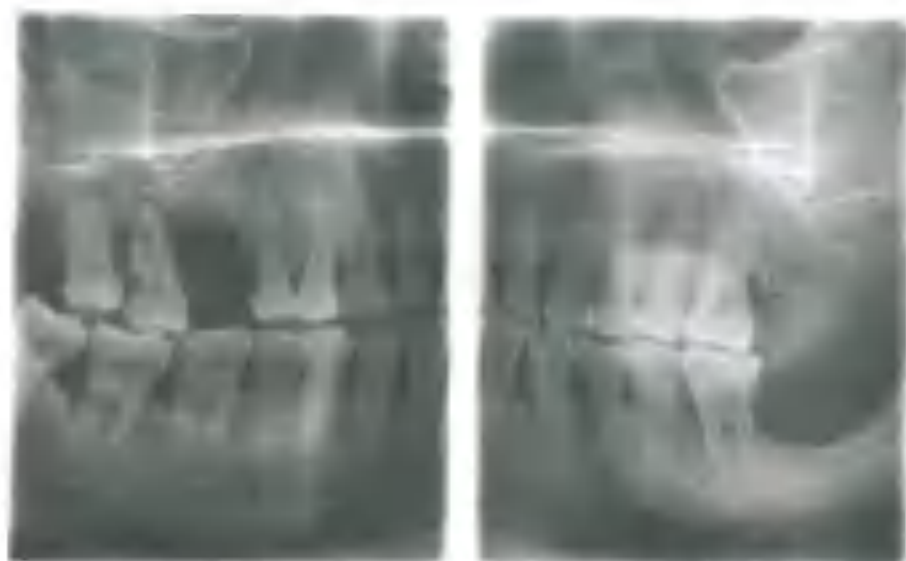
Bitewing radiographs obtained with a panoramic unit. Note distinct radiolucencies in the upper right second molar and premolar.
